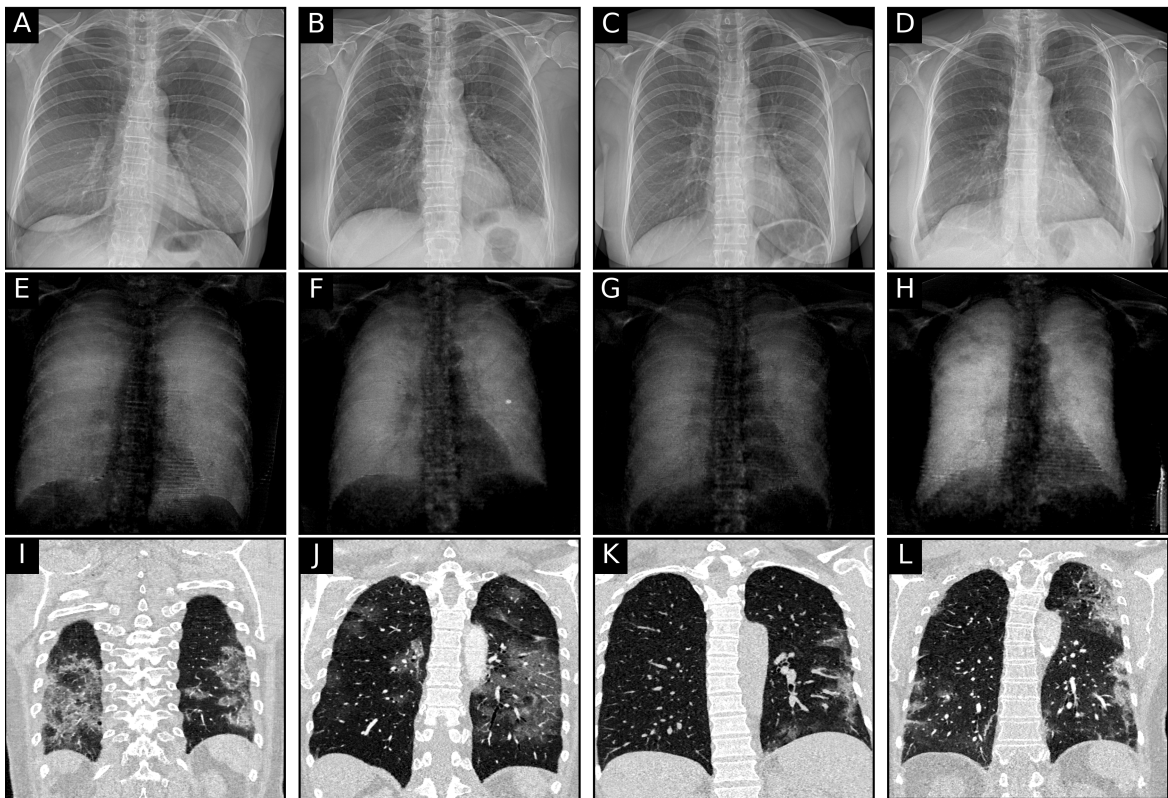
and Figure 6.3 show X-ray dark-field imaging results on COVID-19 patients. Figure 6.2 depicts dark-field (A, C) and attenuation radiographs (B, D) of a healthy participant (A, B) and subject with COVID-19-pneumonia (C, D). Figure 6.3 depicts imaging results of four additional patients infected with COVID-19, more precisely, further attenuation images (A-D), dark-field images (E-H), and respective coronal CT slices of the patient (I-L). Compared to dark-field images in healthy subjects (Figure 6.2A), those in patients with typical COVID-19-pneumonia in the CT scan showed an overall decrease of the dark-field signal (Figure 6.2C, Figure 6.3E-H). While dark-field images in healthy subjects exhibit a relatively homogeneous structure [Gassert, 2021], images of COVID-19 patients appear rather inhomogeneous and patchy, especially in the lung periphery. Whereas changes are evident in dark-field images, conventional X-ray images of healthy subjects (Figure 6.2B) and infected patients (Figure 6.2D, Figure 6.3A-D) are difficult to distinguish.
